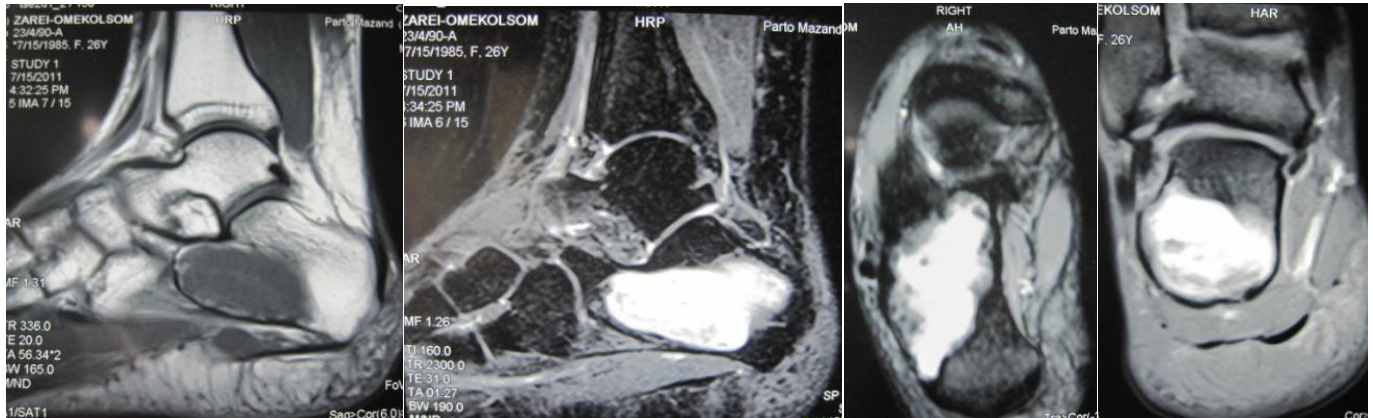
Right side MRI.
